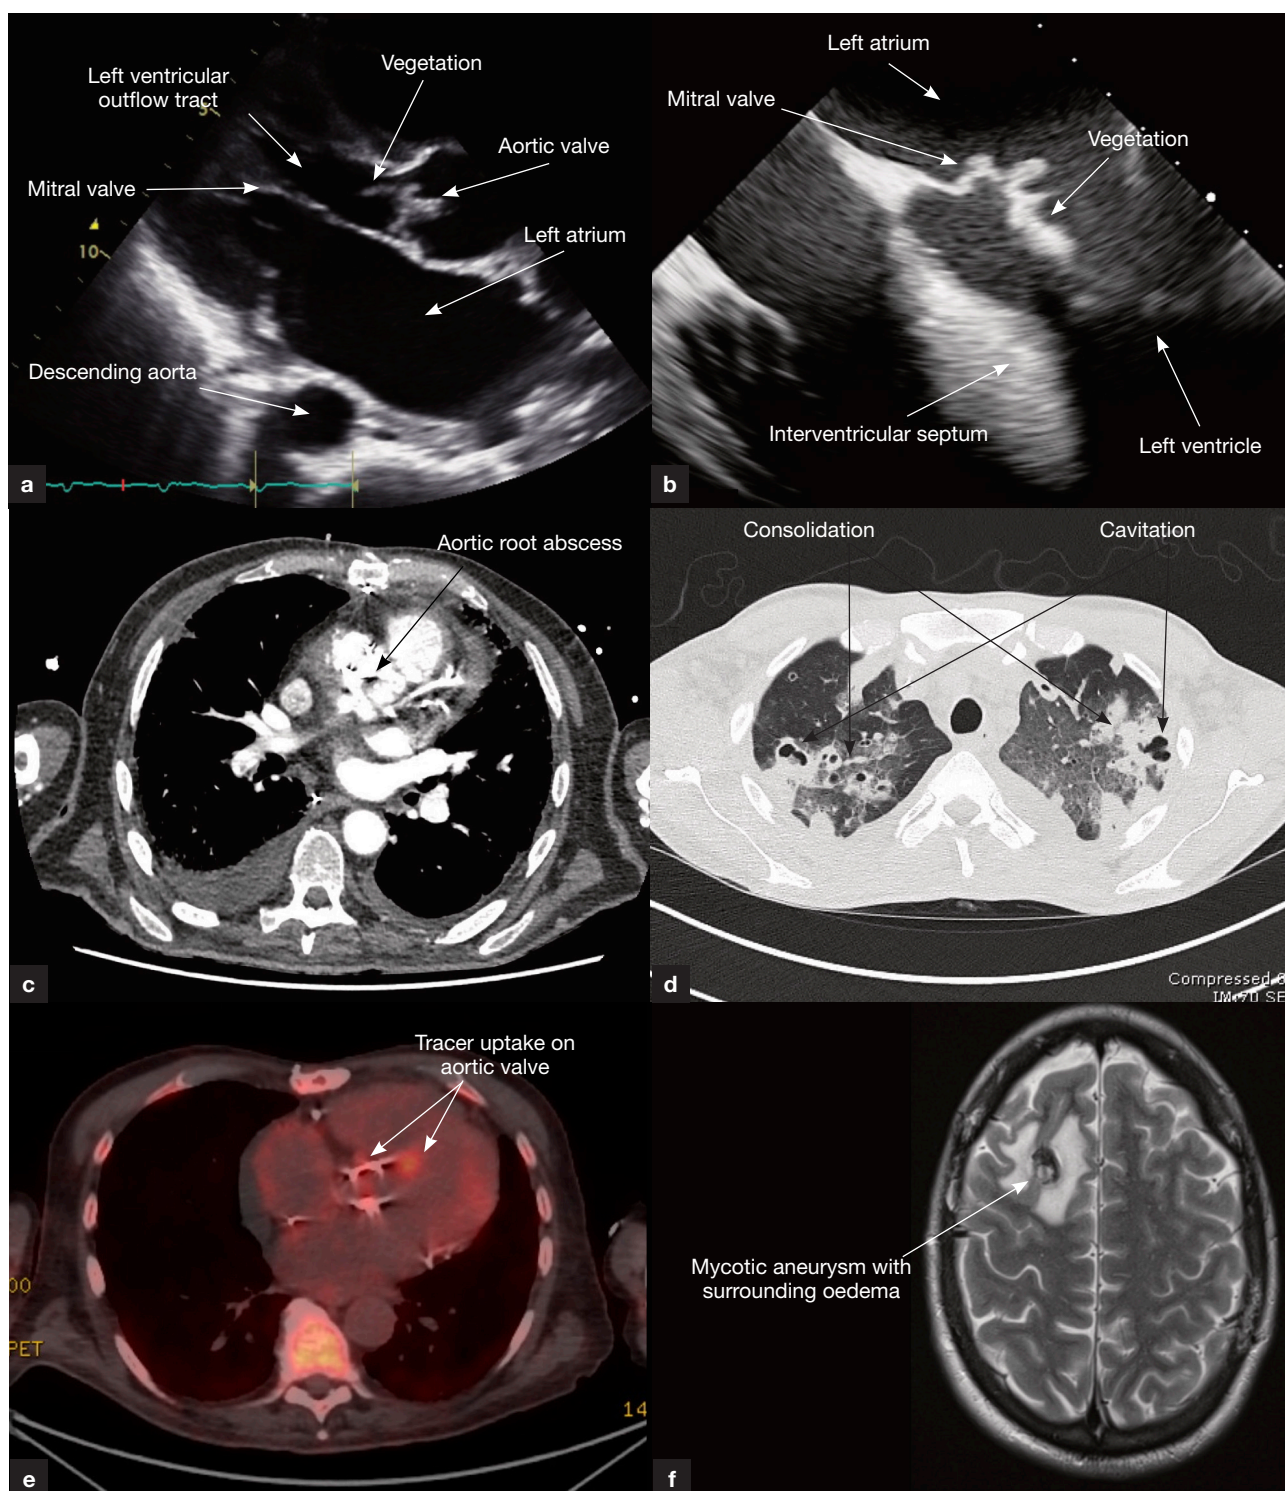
Imaging modalities used in the assessment of infective endocarditis. a. Transthoracic echocardiogram (parasternal short axis) demonstrating an aortic valve vegetation, seen within the left ventricular outflow tract, from the right coronary cusp. b. Transoesophageal echocardiogram (mid-oesophageal four-chamber) demonstrating a vegetation on the anterior leaflet (A2 scallop) of the mitral valve with additional valvular perforation. c. Computed tomography scan, with contrast, of the aorta demonstrating an aortic root abscess (large contrast-filled cavity in the left ventricular outflow tract) seen in the axial plane. d. Computed tomography scan, without contrast, of the thorax demonstrating extensive bilateral pulmonary consolidation and cavitation in a patient with endocarditis, seen in the axial plane. e. Positron emission tomography-computed tomography scan demonstrating moderate tracer uptake within a prosthetic aortic valve replacement, suggestive of prosthetic valve endocarditis, seen in the axial plane. f. T2-weighted magnetic resonance imaging of the brain demonstrating a right frontal mycotic aneurysm with surrounding oedema in a patient with endocarditis.
